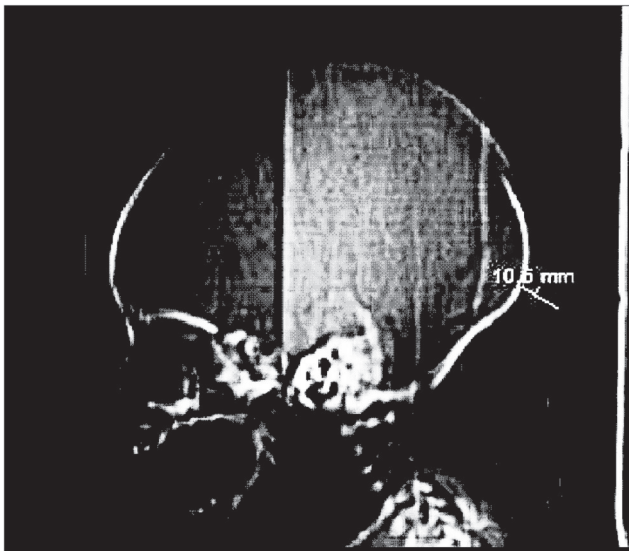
Panoramic CT scan of the patient No.1.
